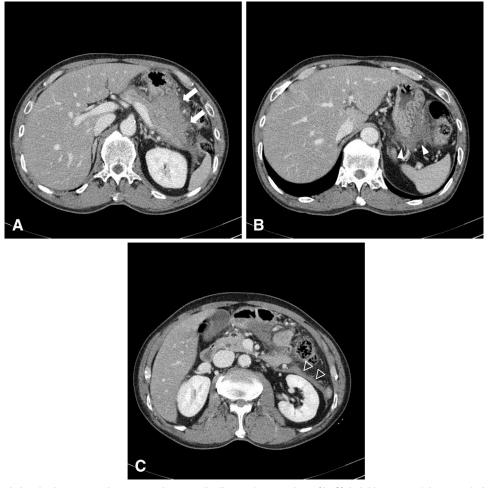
Initial abdominal computed tomography scan findings of our patient. (A–C) Axial images of the portal phase show focal swelling of the pancreatic body and tail (arrows, (A) with peripancreatic, perigastric (arrowheads, (B), and left pararenal space (blank arrowheads, C) fluid collection, suggesting acute pancreatitis. The normal appearance of the spleen, both kidneys, and inferior vena cava can also be seen.
